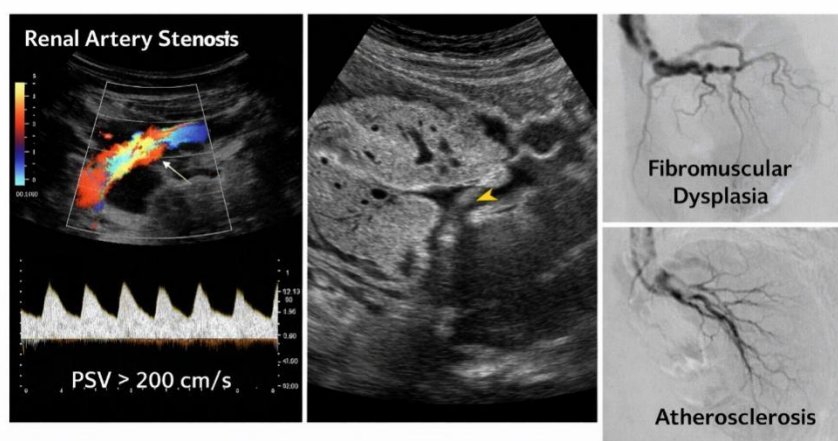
Doppler Ultrasound of Renal Artery
